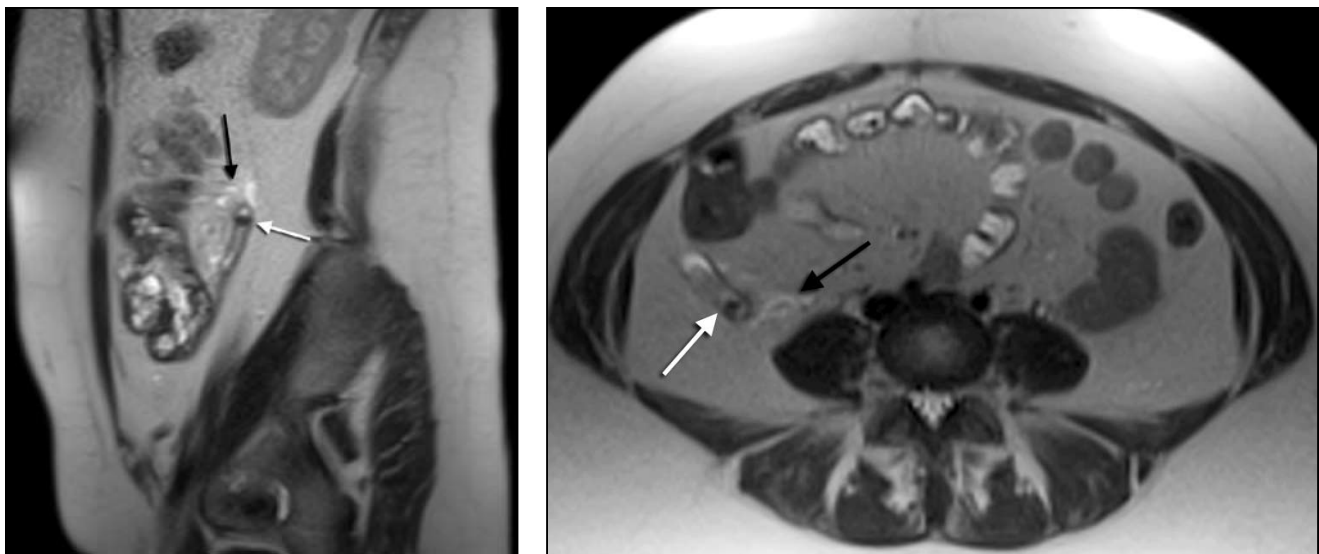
Acute appendicitis in a 34 year old pregnant patient with a six-week four-day gestation. Sagittal T2-weighted single shot fast spin echo (SSFSE) [left] and axial T2-weighted SSFSE [right] MR images demonstrate the retrocecal, dilated fluid filled appendix containing an appendicolith (white arrow) and peri-appendiceal inflammation (black arrow).
